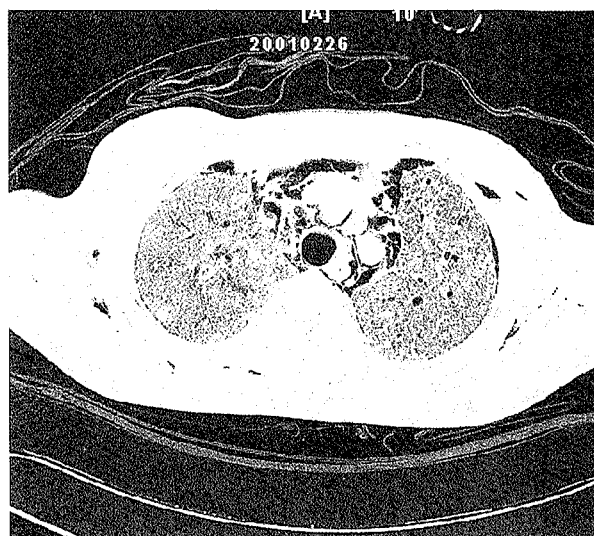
Pneumomediastinum--Chest CT.
